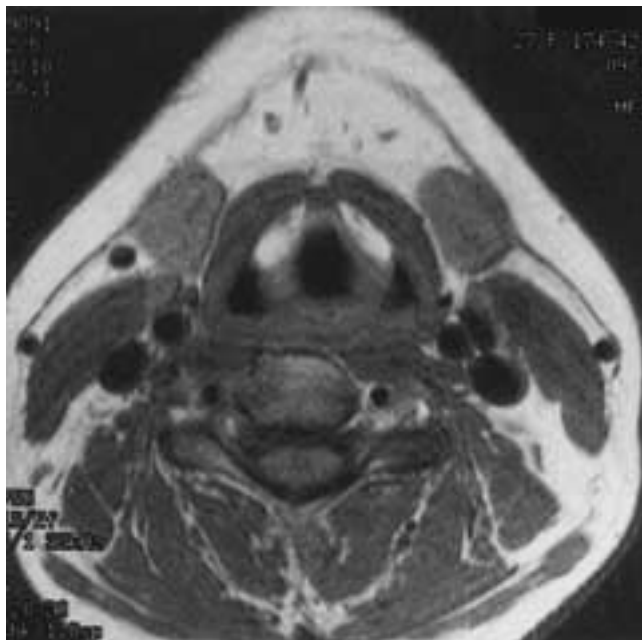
FSE T1-weighted image through the larynx. Axial 512 × 256 matrix shows excellent detail in the paraglottic space and pyriform sinuses.
